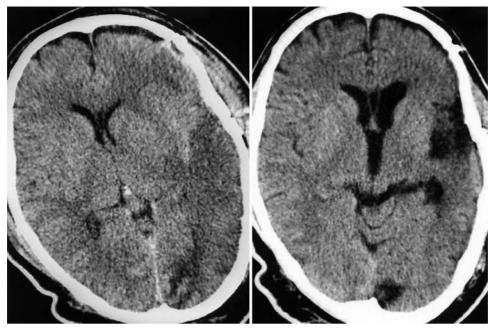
Case 9. Axial CT scans obtained in a patient with SAH, demonstrating reversal of low-attenuation changes after multiple papaverine infusions. *Left:* Prepapaverine CT scan obtained on post-SAH Day 7. *Right:* Postpapaverine CT scan obtained on post-SAH Day 151.
